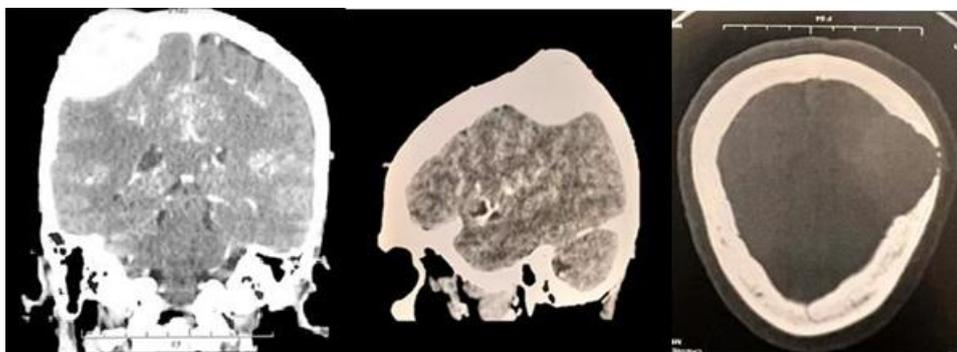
CT images of plasmacytoma of the right parietal vault mimicking a meningioma.
